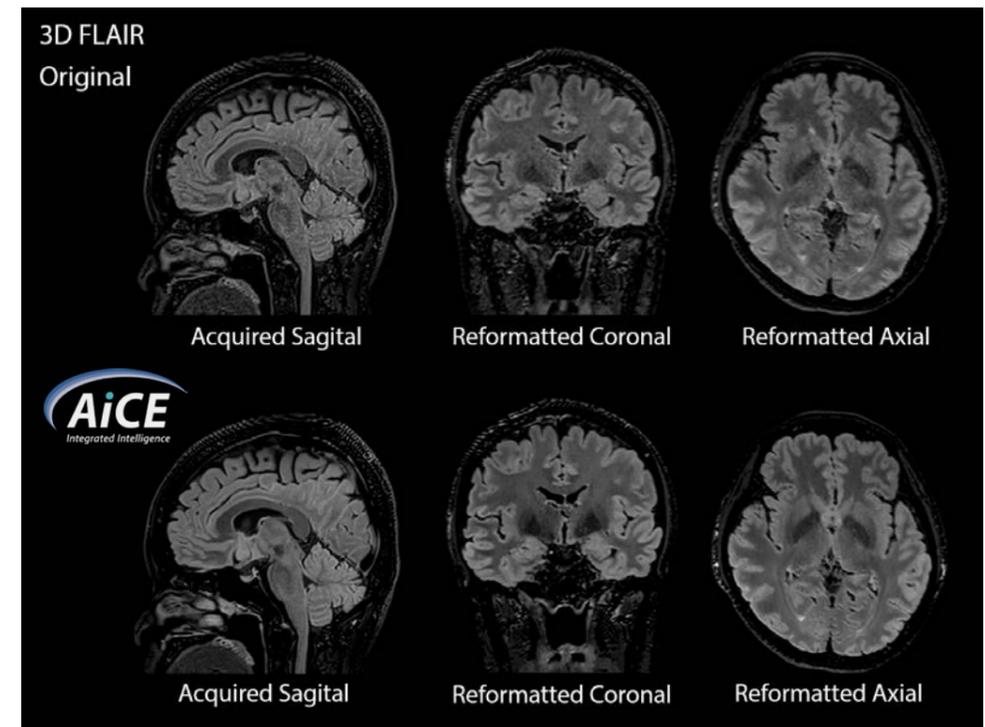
Typical 3D FLAIR images with and without AiCE denoising. Scan time: 1 min 40 s.
